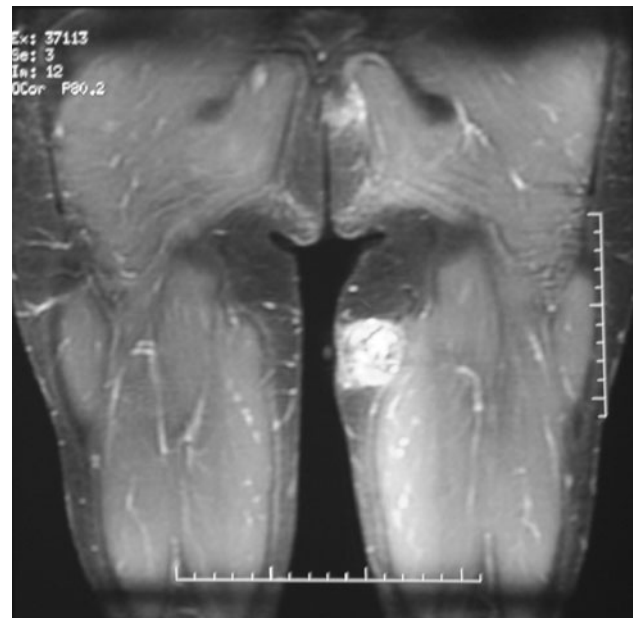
MRI of the thigh shows a 4 × 3 × 2.5-cm diameter soft tissue mass, which was hyperintense on T2-weighted and hypointense on T1-weighted images in the medial side of the left thigh.
